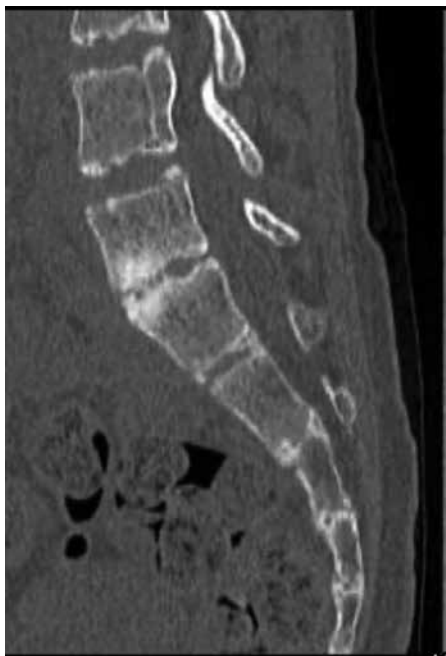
Postoperative CT scan of the lumbar spine CT scan at 12 months postoperatively showing the presence of bridging callus that suggests a tendency to bony fusion.
